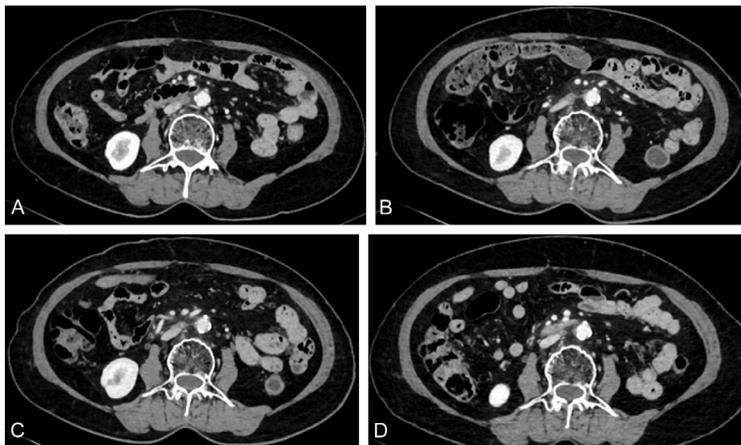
Serial imaging demonstrating treatment response to slurilizumab. A. computed tomography (CT) scan after 4 months of slurilizumab treatment. B. CT scan after 6 months of slurilizumab treatment. C. CT scan after 9 months of Slurilizumab treatment. D. CT scan after 12 months of slurilizumab treatment.
